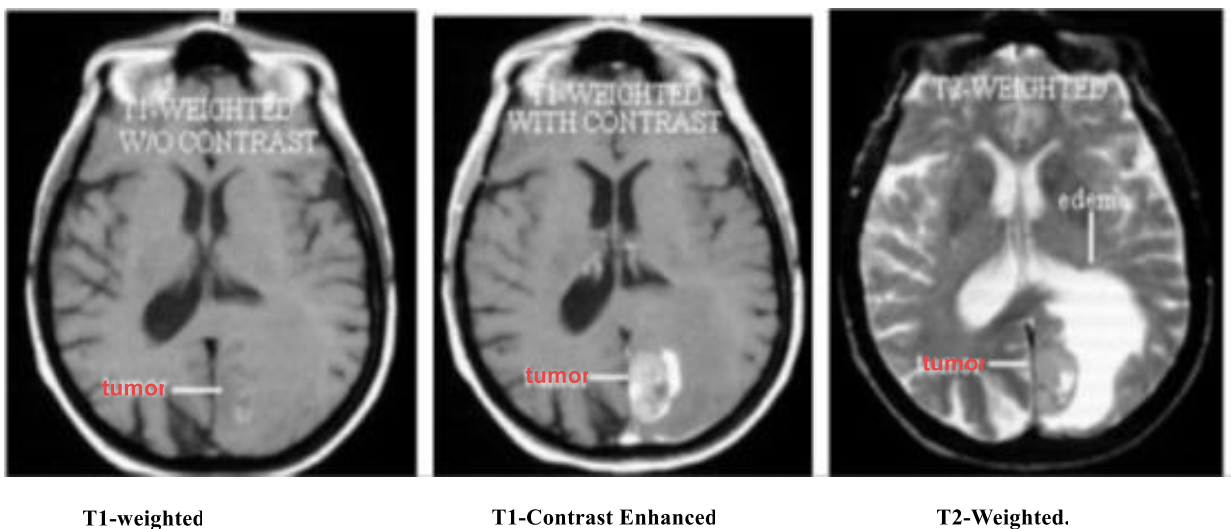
MRI brain images.
